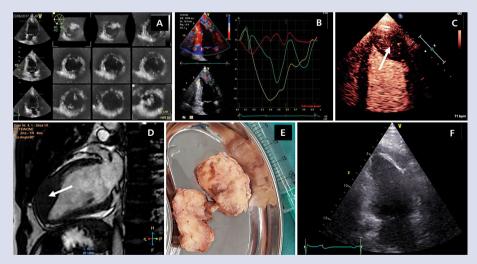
A. Transthoracic three-dimensional echocardiography; B. Tissue Doppler echocardiography (the red curve indicates very low values of systolic strain at the tumour site; green and yellow curves present normal values of systolic strain in anterior and posterior left ventricular walls, respectively); C. Contrast echocardiography; D. Cardiac magnetic resonance; E. Intraoperative photography of the excised tumour; F. Control transthoracic echocardiography
